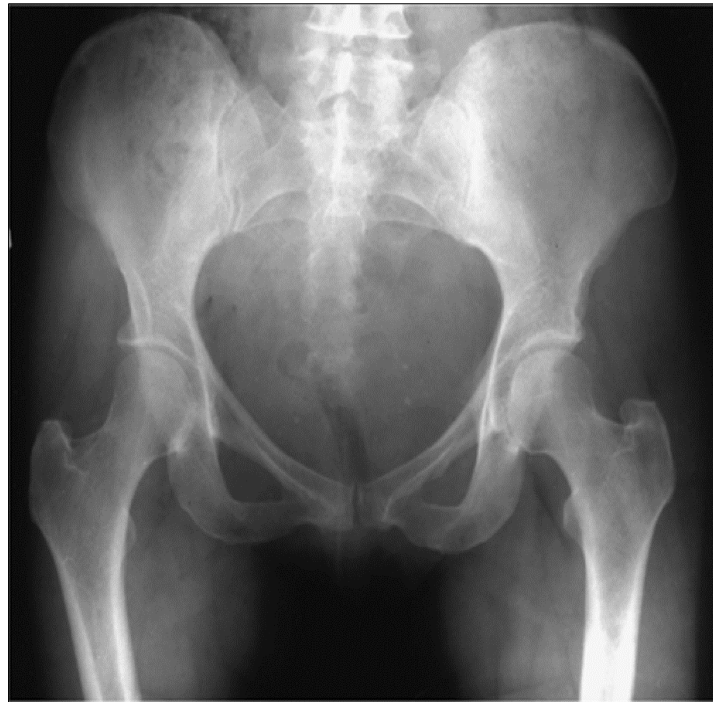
Plain Xray of the Male Pelvis (AP view)
